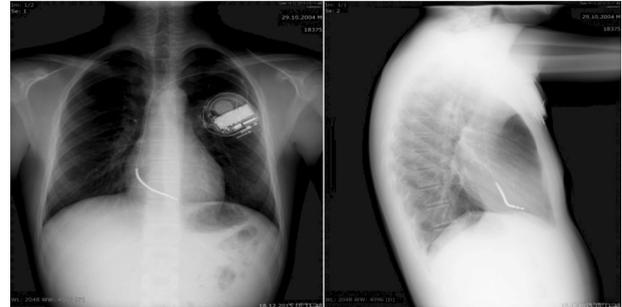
Xray of the chest – visualisation of intra-cardiac converter/defibrillator
